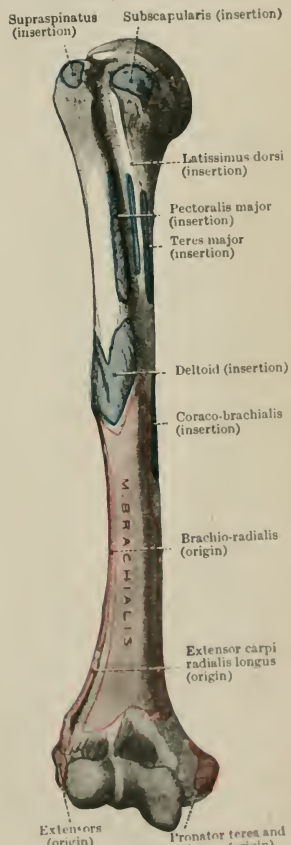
THE ANTERIOR ASPECT OF THE HUMERUS, WITH MUSCLE ATTACHMENTS.
